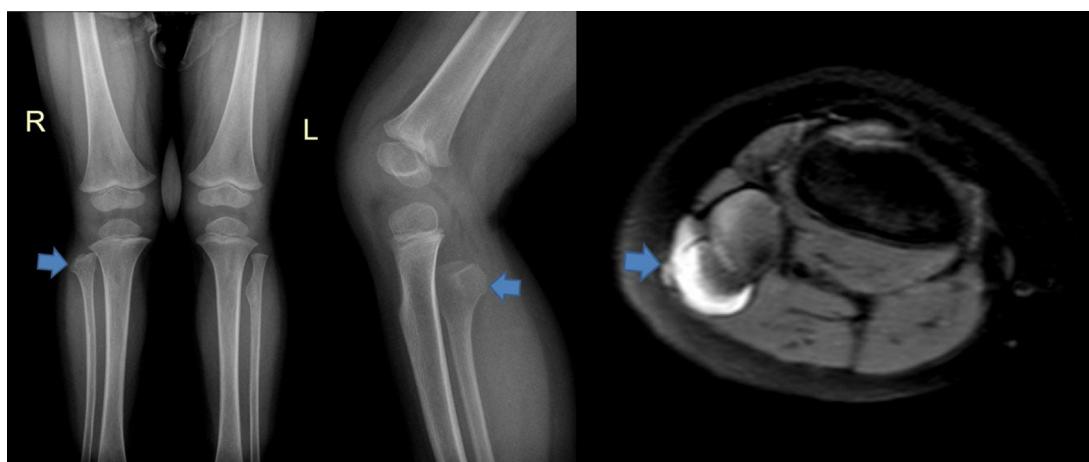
Plain X-rays and MRI demonstrating posterolateral osteochondroma of the proximal fibula.
